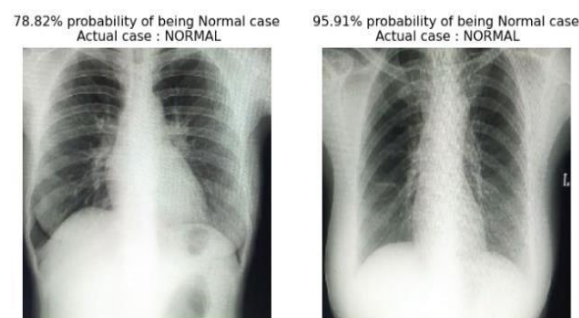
Chest X-ray images predicted by the model
